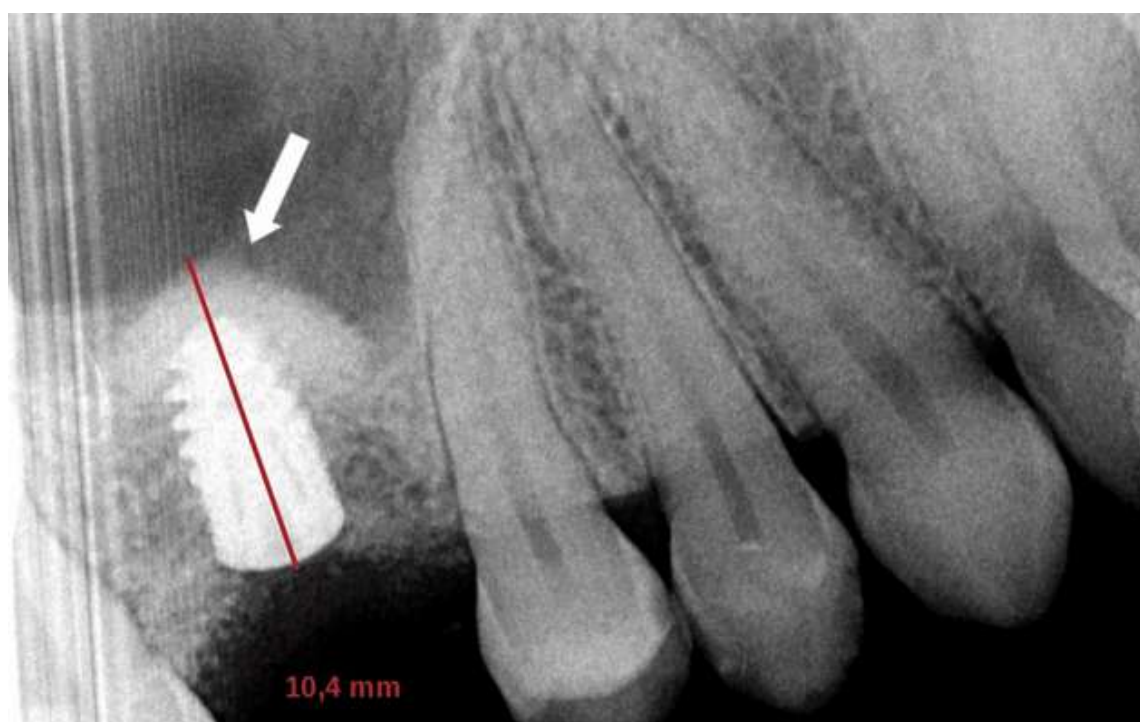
Periapical x-rays of the right upper first molar region after implant insertion
